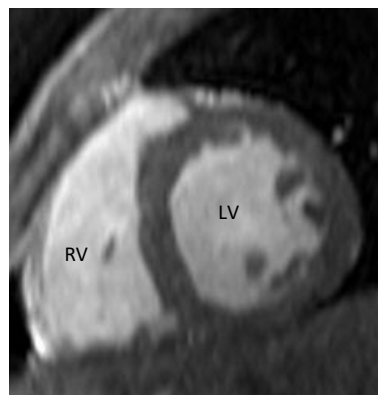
Bright-blood T1-weighted short axis image through the mid aspect of the right and left ventricles (RV and LV). The dark appearance of the myocardium is clearly distinguishable from the bright intracavitary blood [44].
